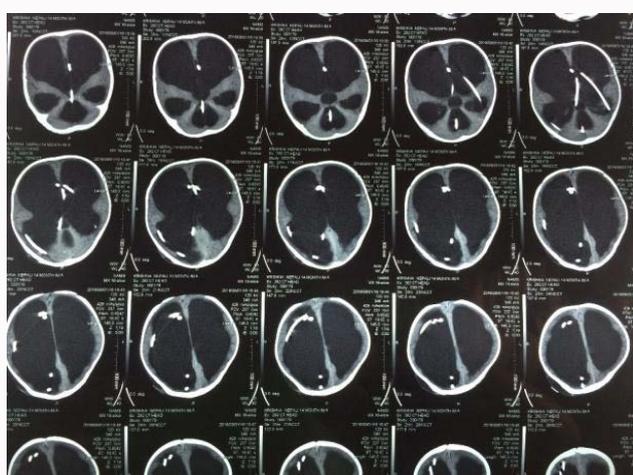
Axial view of brain CT scan reveals shunt migration inside ventricles with hydrocephalus.
